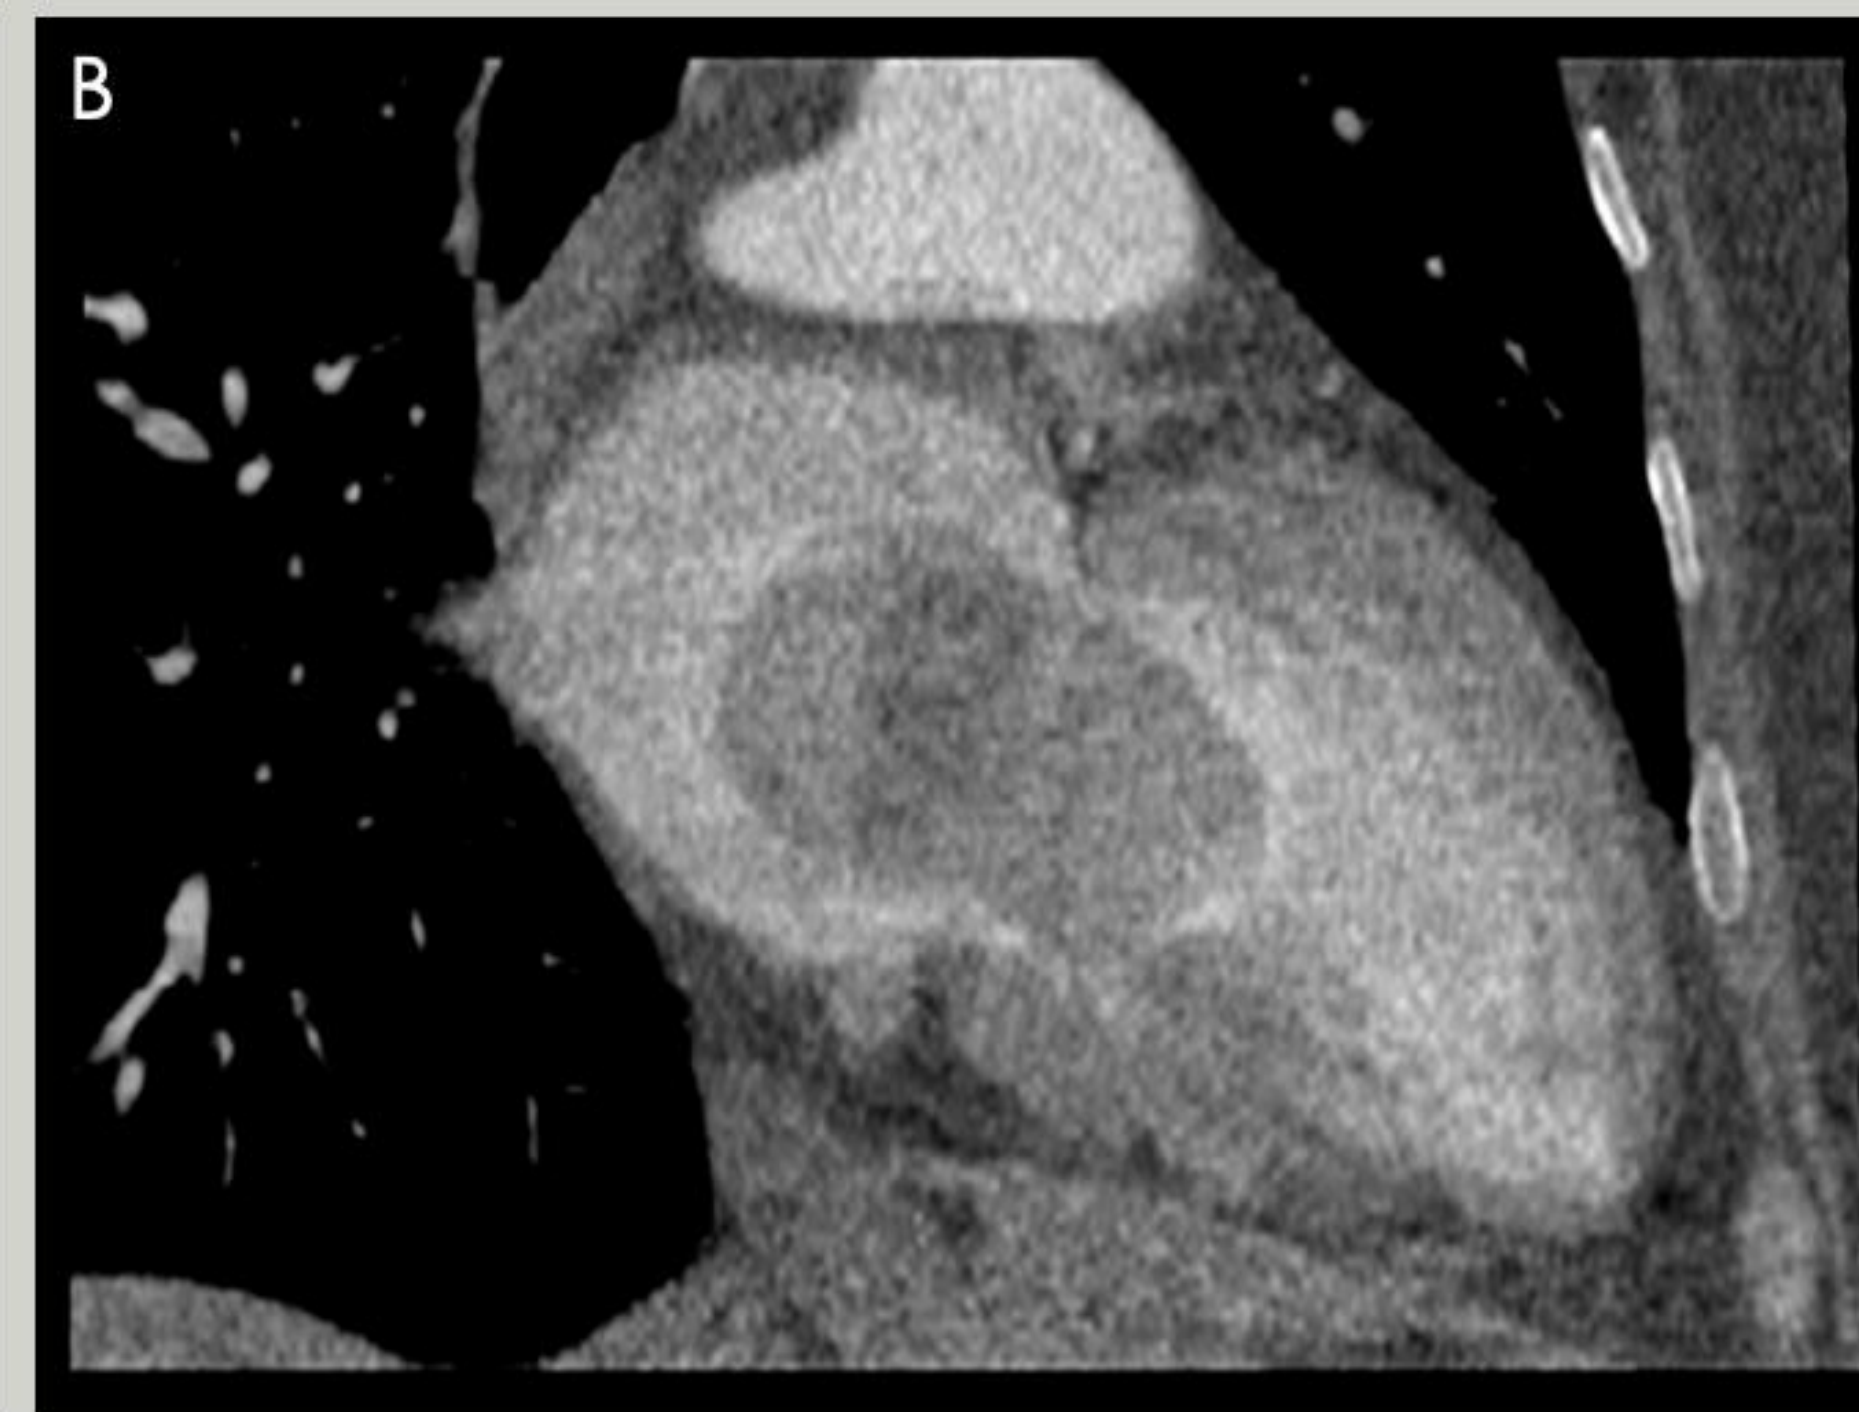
Cardiac CT - 4 chamber view demonstrating a 3.8 x 5.6 cm mass left atrial mass attached to the interatrial septum (3A). 2 chamber view demonstrated prolapse of the mass across the mitral valve (3B).
